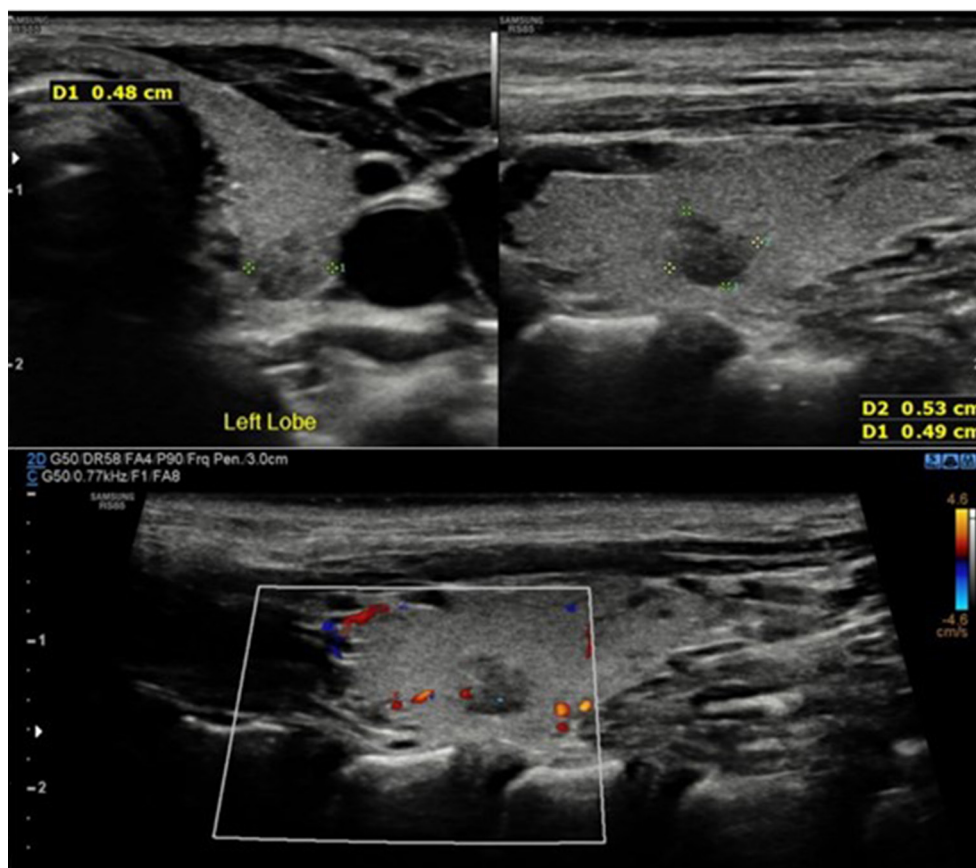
Ultrasound of thyroid gland with regular contour and normal dimensions, presenting solid, heterogeneous echotexture due to nodular images described below. Nodule in right lobe measured 2.4 cm × 0.9 cm × 0.3 cm on the largest axes (V: 1.0 cm³). Nodule in isthmus measured 1.3 cm × 0.1 cm × 1.1 cm on the largest axes (V: 0.07 cm³). Nodule in left lobe measured 2.4 cm × 0.9 cm × 0.9 cm on the largest axes (V: 1.0 cm³). Total volume approximately 2.0 cm³. Solid nodular image, predominantly hypoechoic, poorly defined margins, taller than wide, located in middle-posterior third of right lobe, measuring approximately 1.0×0.5×0.3. TI-RADS 5. Solid nodular image, predominantly hypoechoic, poorly defined margins, taller than wide, located in middle-posterior third of left lobe, measuring approximately 0.5×0.5×0.5. TI-RADS 5. The white box is marking the nodules' area. V, volume; TI-RADS, Thyroid Imaging Reporting and Data System.
